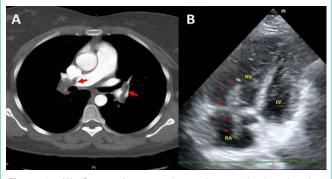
(A) Computed tomography angiogram showing thrombus involvement of the right and left main pulmonary arteries. (B) Echocardiography showing multilobular mobile mass in the right atrium prolapsing across the tricuspid valve into the right ventricle, consistent with a thrombus-in-transit.
